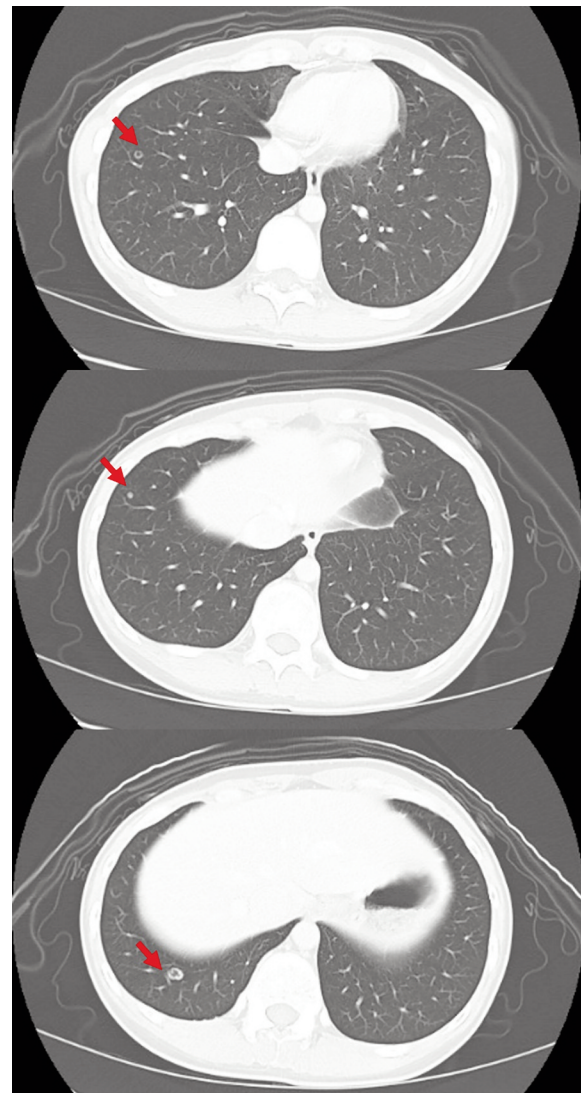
Computed tomography images taken at the time lung metastases appeared. Nodular, ring-shaped areas are seen at three locations in the right lung (arrows indicate lung metastases).
